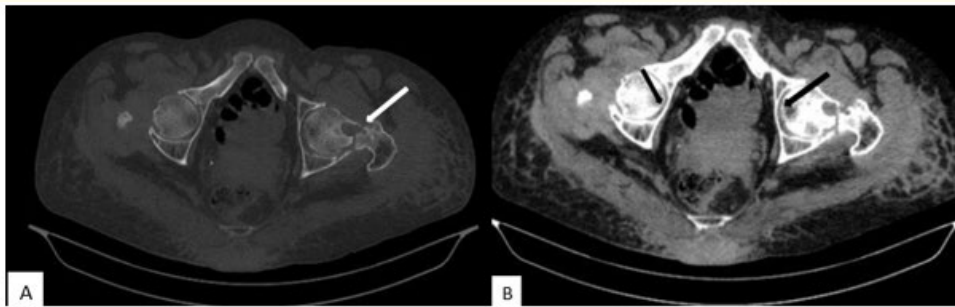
Axial slices of a pelvic CT scan in bone window (A) and soft tissue window (B) showing a fracture line of the left femoral neck passing through the osteolytic lesion, associated with bilateral thickening of the articular synovium.
